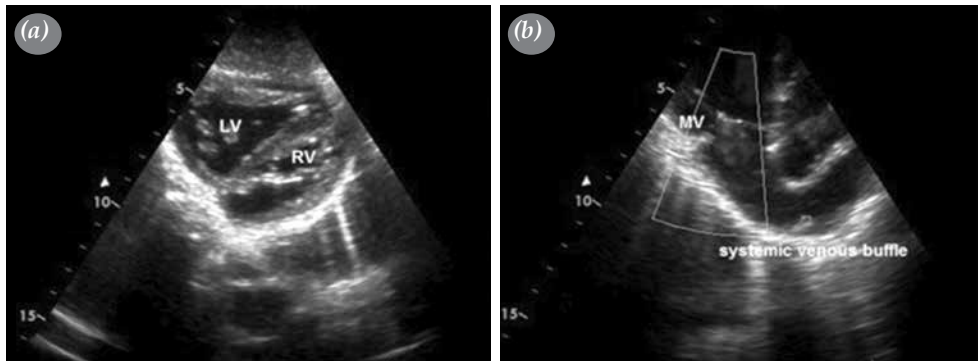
(a) Postoperative transthoracic echocardiography showing left and right ventricles and (b) an unobstructed systemic venous baffle.
